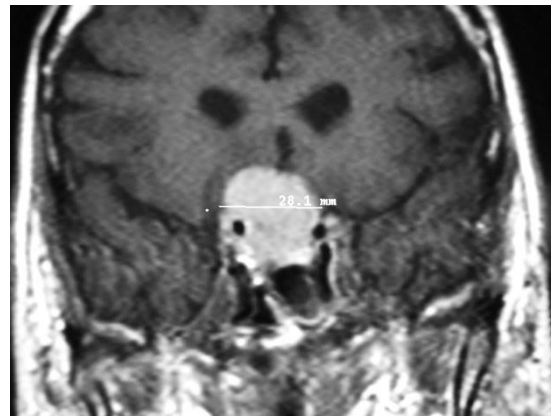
MRI (coronal view) of a suprasellar meningioma affecting planum sphenoidale and right cavernous sinus.
